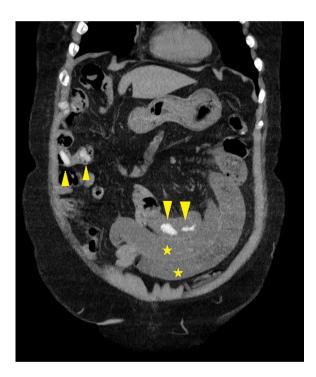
Computed tomography with coronal view reconstruction demonstrating a high-density lesion in the small bowel (arrowhead) and dilated intestine (star)
